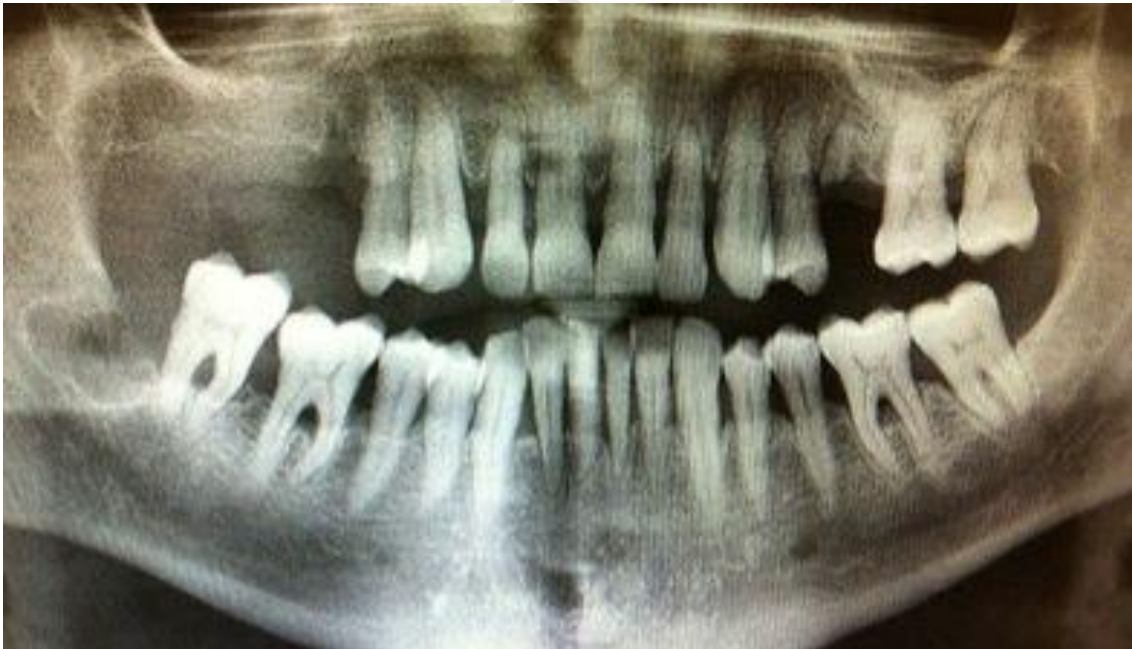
Panoramic radiograph 2 weeks after the extraction, where no alterations can be observed.
